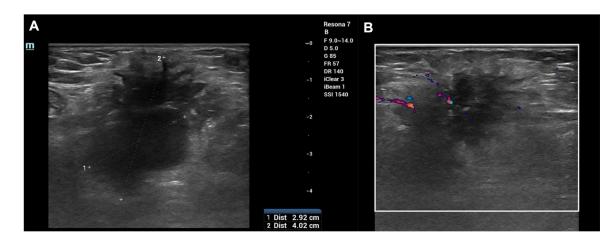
Diagnostic ultrasound of the left breast: (A) B-mode and (B) color Doppler. (A) There is a 4 cm irregular hypoechoic mass with not-circumscribed margins and associated mild posterior shadowing, anti-parallel orientation. (B) At the color Doppler assessment there is internal and peripheric vascularization. The lesion is highly suspicious for malignancy (BI-RADS 4C) and correlates with the mammographic findings.
